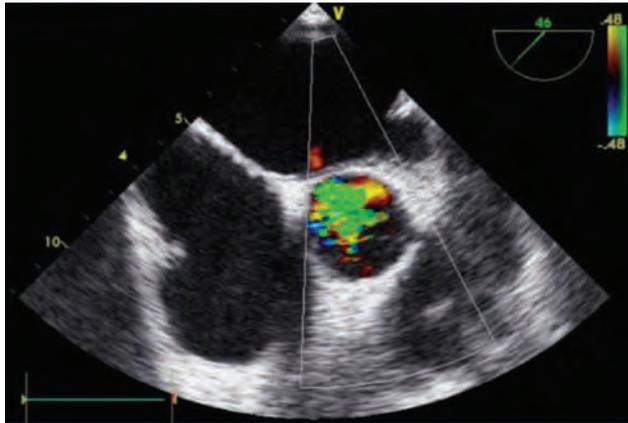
Transesophageal echocardiographic view of aortic prosthetic leak.
